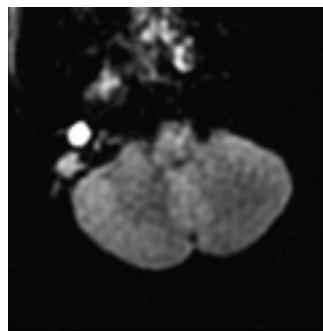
PROPELLER HD DWI
